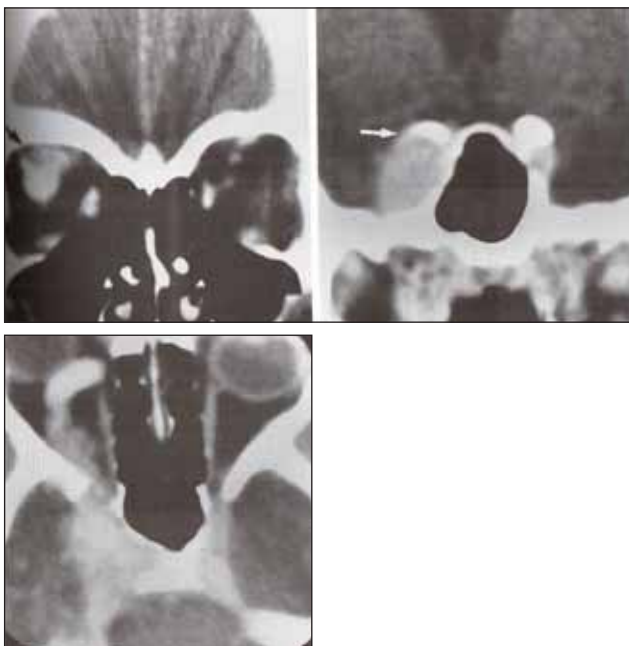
First patient-carotid cavernous fistula shown by CT
